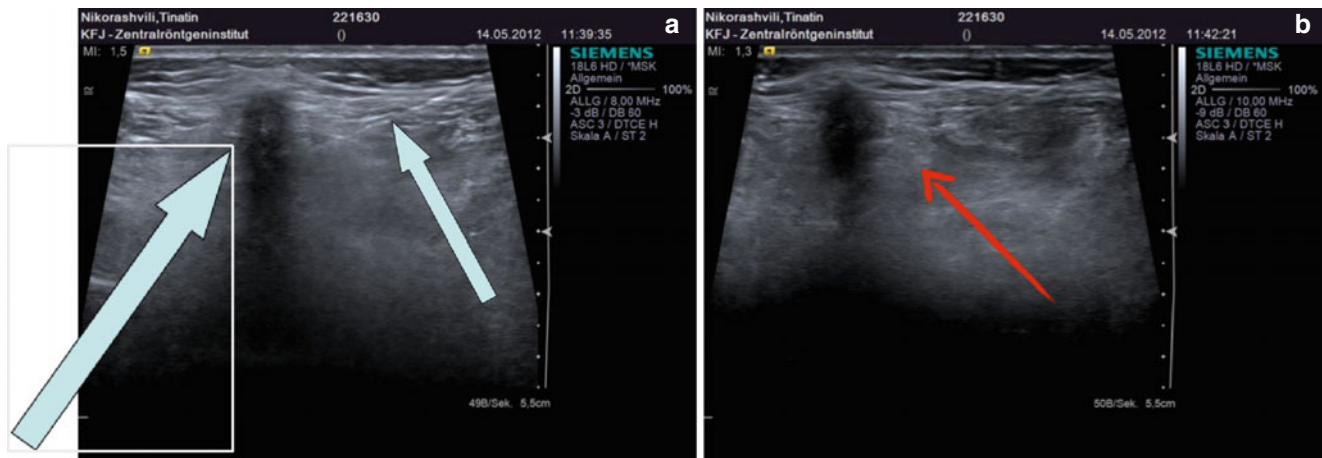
Ultrasound-guided interventions: Blood patch and ultrasound. A patient developed a CSF fistula after repeated lumbar puncture for the prophylactic treatment of lymphoma. An initial “blind” blood patch was not effective. Under US guidance a successful blood
